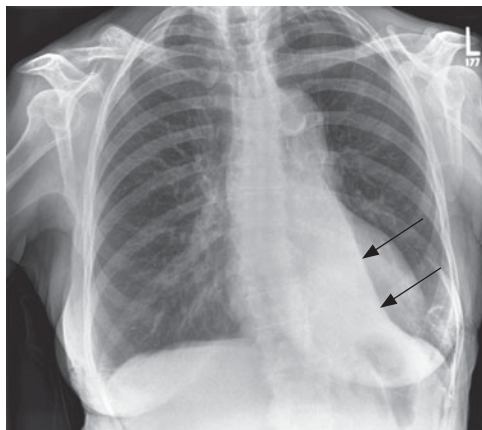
PA chest radiograph with 'sail sign' indicated.
